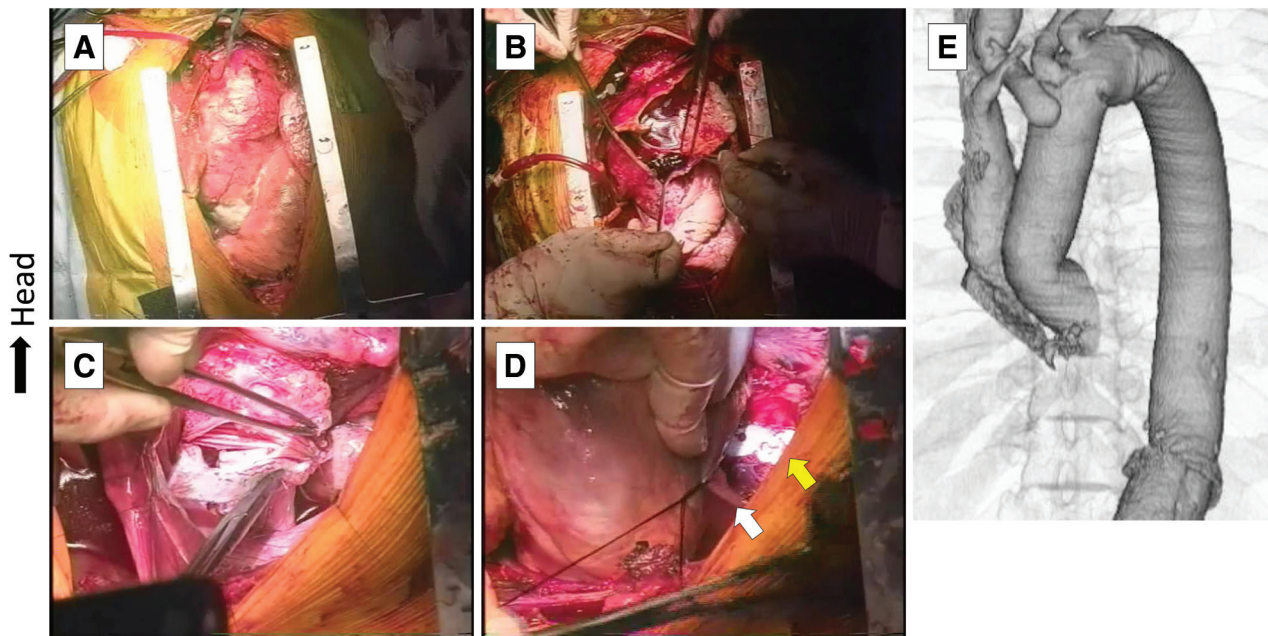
Exposure of the distal descending thoracic aorta through a median sternotomy with left pleurotomy. (A) Ascending aorta after sternotomy. (B) After the ascending aorta was opened. (C) Distal anastomosis using the pull-through technique. The distal descending aorta was exposed through the left pleurotomy after the heart was displaced to the right along with the pericardium. (D) Distal anastomotic site (yellow arrow) and the pericardium (white arrow) while the heart was being returned to the original position. (E) Postoperative 3-dimensional computed tomography.
